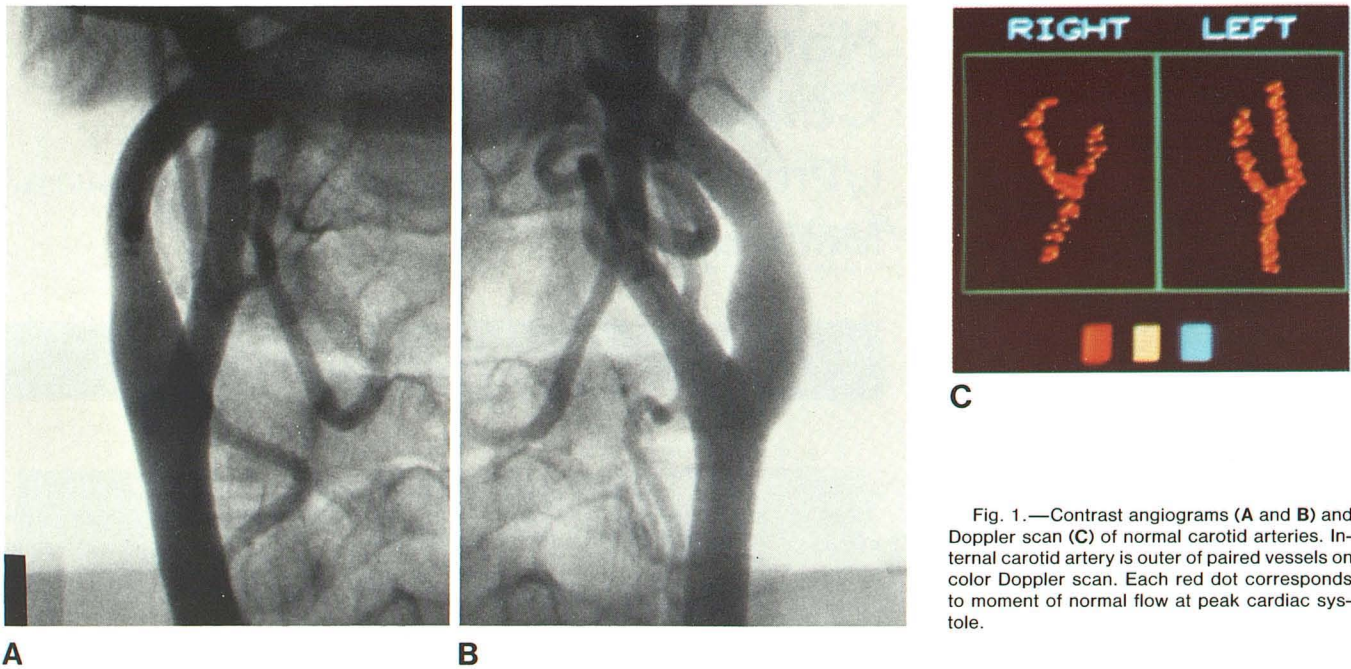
Contrast angiograms (A and B) and Doppler scan (C) of normal carotid arteries. Internal carotid artery is outer of paired vessels on color Doppler scan. Each red dot corresponds to moment of normal flow at peak cardiac systole.
